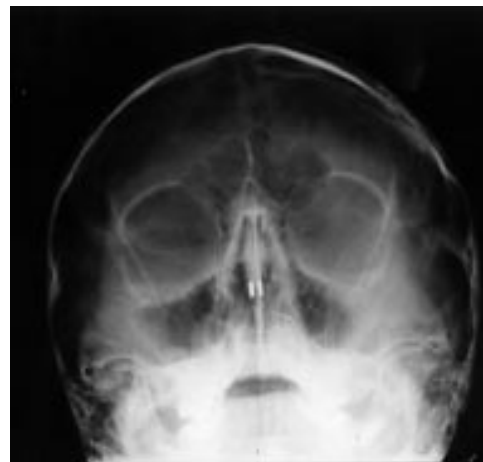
Radiograph showing the magnets on either side of the septum.
